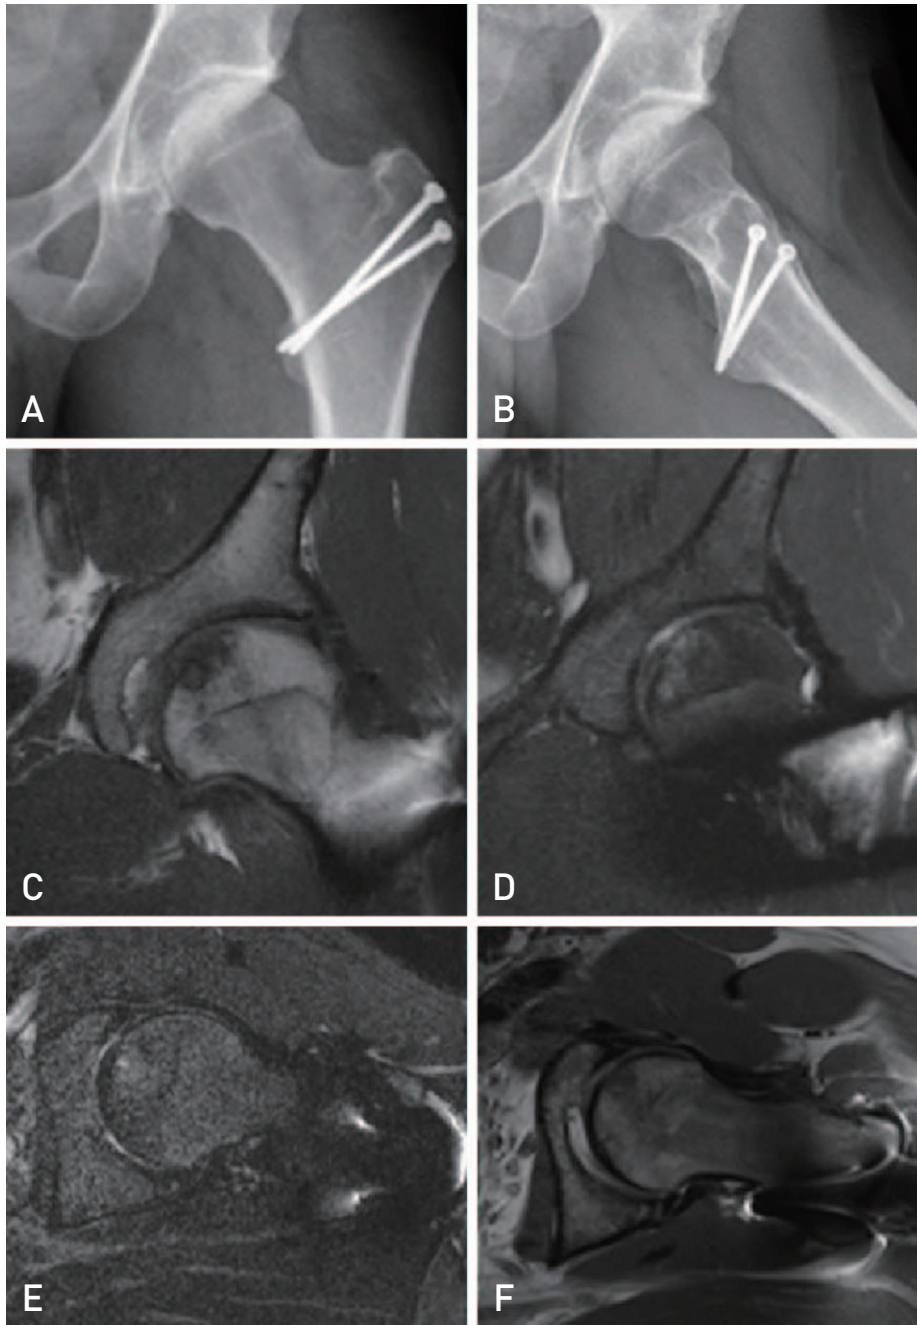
Postoperative imaging studies. (A) Anteroposterior and (B) lateral radiographs at final follow-up without progressive degenerative changes. (C) Coronal T1-weighted and (D) fat-saturated T2-weighted, and (E) axial STIR (short-TI inversion recovery)-weighted and (F) fat-saturated T2-weighted magnetic resonance imaging images showing adequate graft union and healthy chondral surface formation.
